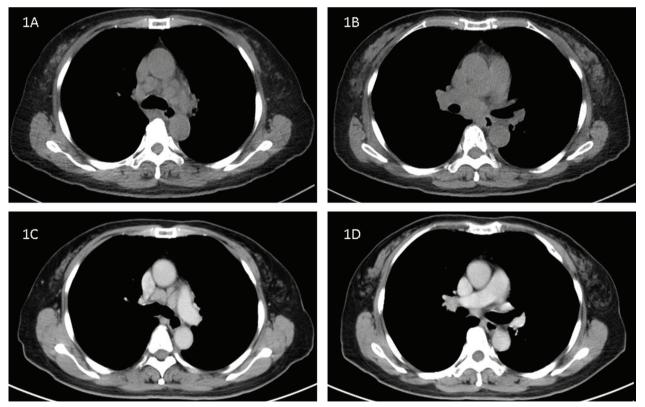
1A. & Fig. 1B. Chest CT showed enlargement of the lymphadenopathy at the upper mediastinum and subcarinal region. Fig. 1C & Fig. 1D. Chest CT after 3 months of treatment disclosed a decrease of the size of the lymphadenopathy.
